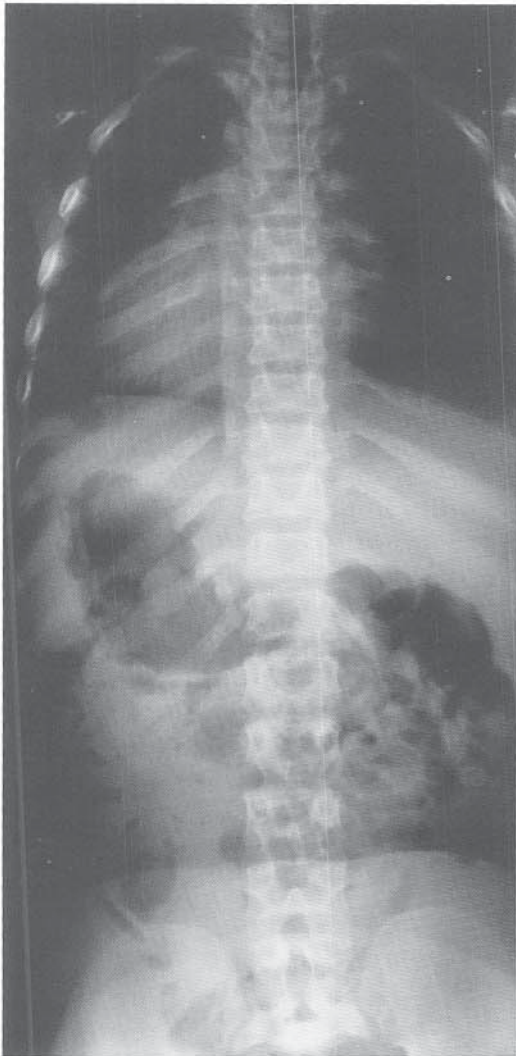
AP radiograph of an achondroplastic spine. The interpedicular distance progressively decreases distally in the lumbar spine rather than increasing.
